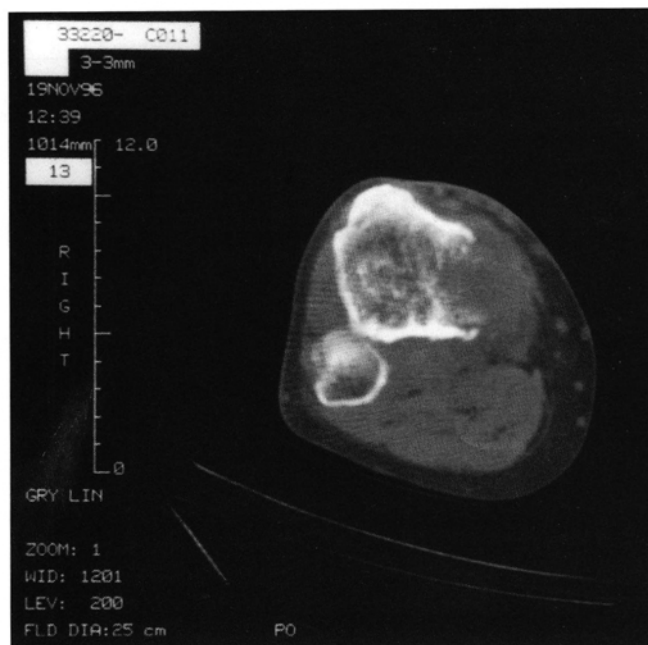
CT of the tibia further characterizes the proximal tibial lesion. Cortical breakthrough medullae with an abnormal soft tissue mass extending into the adjacent soft tissue is shown.
